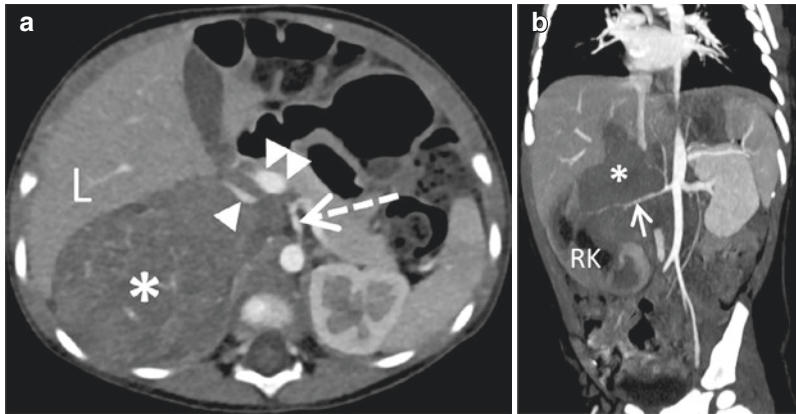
A 12-month-old girl with localized (MYCN-amplified) right adrenal neuroblastoma (asterisks). Contrast-enhanced CT scan with transverse view (a) and coronal MIP reconstruction (b). IDRFs are present: encasement of the right renal artery (arrow), infiltration of the hilum of the right kidney (RK), and encasement of the inferior vena cava (arrowhead). Some relationships with adjacent organs are not IDRf: the liver (L) is displaced without direct infiltration; the celiac artery (dotted arrow) is separated from the tumor; the portal vein (double arrowhead) and the aorta are in contact with the tumor, without encasement
